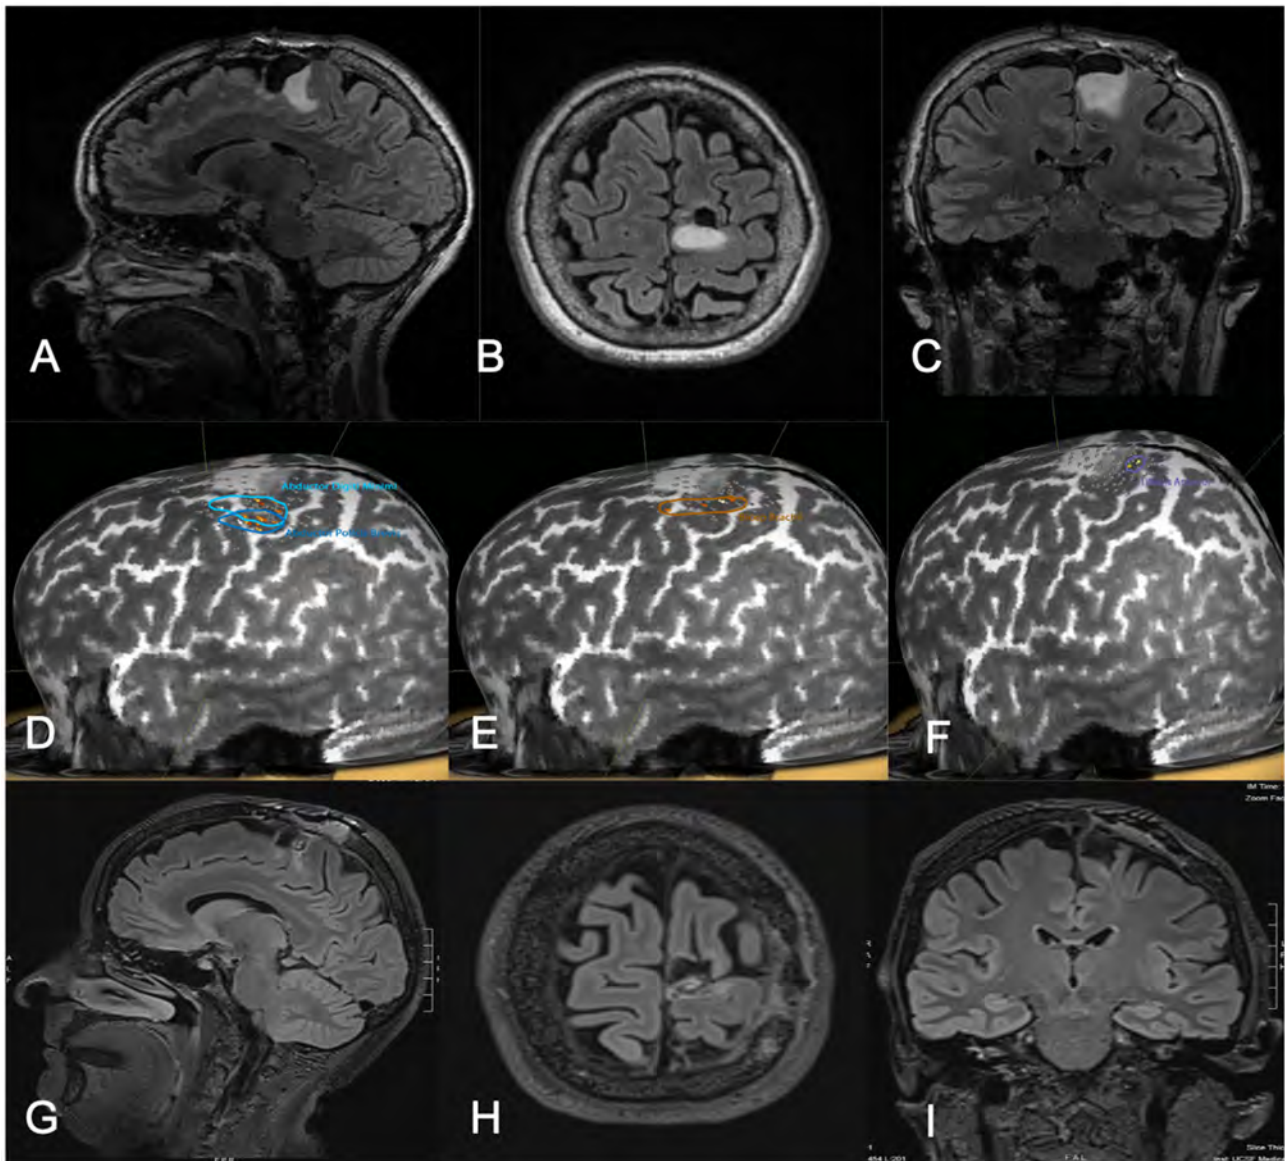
Fifty-one-year-old female with a history of left parietal oligodendroglioma status post prior subtotal resection, now presenting with recurrence (T2 FLAIR imaging, A–C). nTMS demonstrated hand and lower extremity motor activity lateral and posterior to the area of prior resection and region of recurrence (D–F). Intraoperative DCS identified lower extremity motor function in close proximity to the area of recurrence, as identified on preoperative nTMS. Subtotal resection was achieved with care taken to spare motor sites intraoperatively (T2 FLAIR imaging, G–I). The patient had no postoperative neurological deficits on neurological examination.
